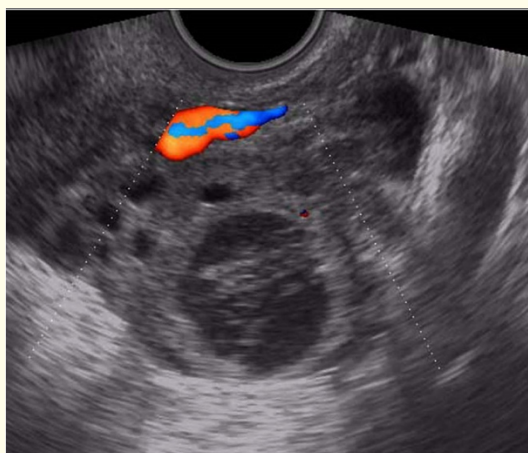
Transvaginal color Doppler ovarian view of a 32-year-old female with LPhD. On the 17th day of the cycle, a cystic formation with a diameter of less than 2 cm with small linear inclusions and 5 antral follicles is visualized in the ovary. In the color Doppler mode, there are no vascular signals on the wall of the cystic formation.
